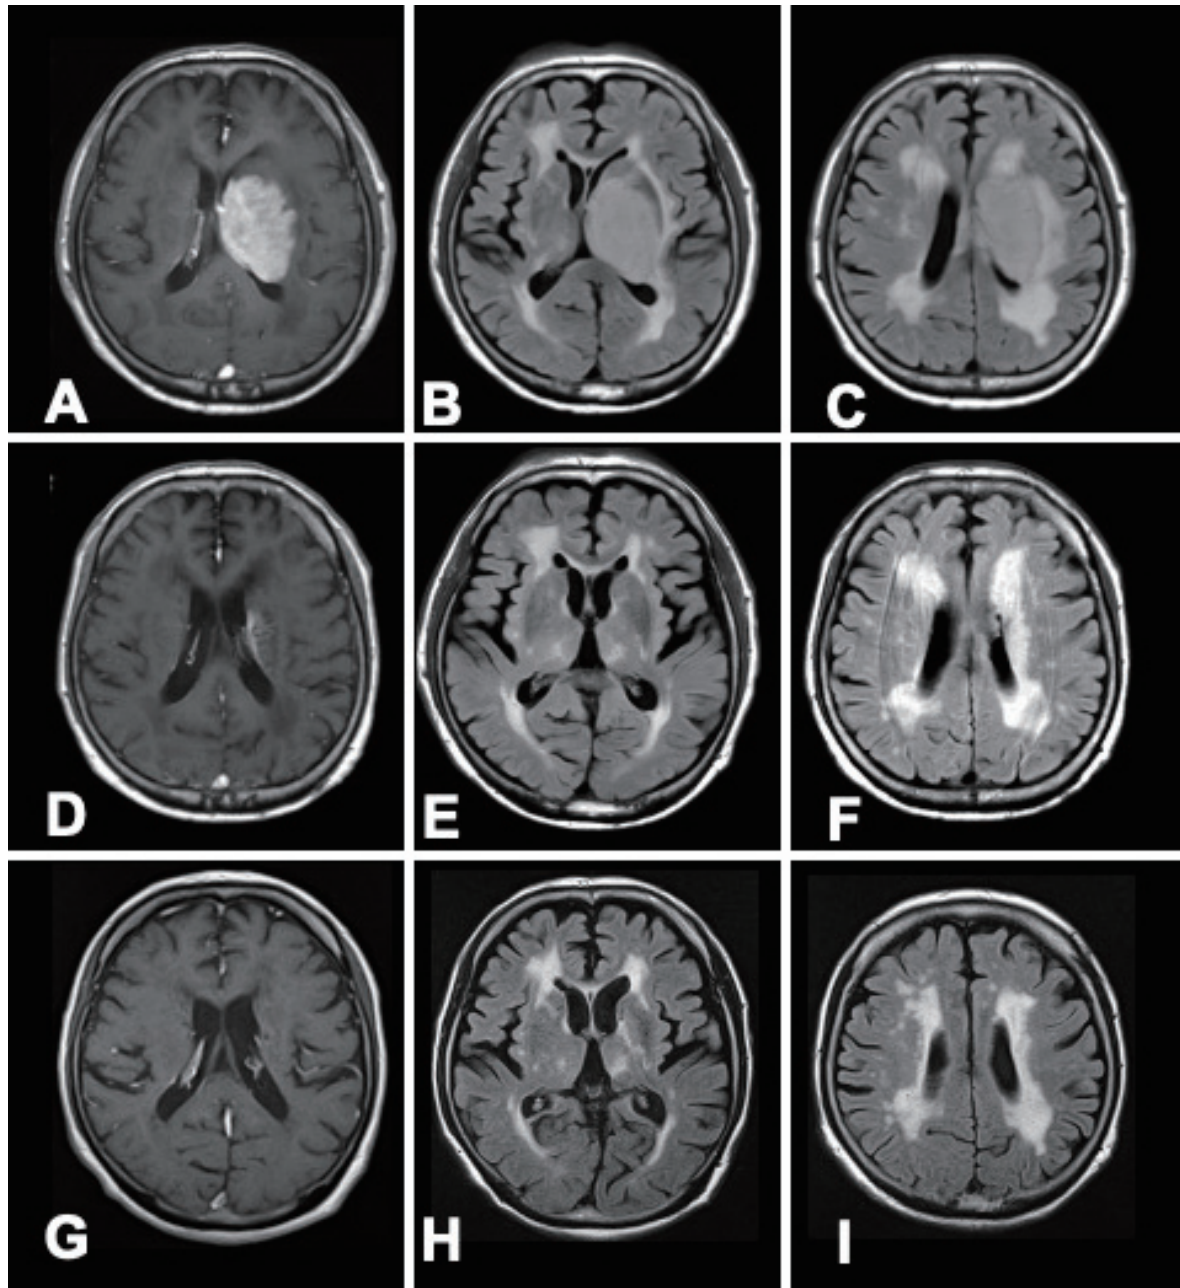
Case 1. (A) Axial Gd-T1, (B) axial FLAIR, and (C) axial FLAIR images prior to treatment initiation. Multiple lesions were identified in the right thalamus and bilateral temporal lobes. Following 5 cycles of R-MPV, residual tumours were still detected in (D) axial Gd-T1, (E) axial FLAIR, and (F) axial FLAIR images. No evidence of tumour development or progressive white matter changes, including leukoencephalopathy, was found in (G) axial Gd-T1, (H) axial FLAIR, and (I) axial FLAIR images taken after 32 months of tirabrutinib treatment. FLAIR: fluid-attenuated inversion recovery; Gd-T1: gadolinium-enhanced T1-weighted imaging; R-MPV: rituximab, high-dose methotrexate, procarbazine, and vincristine
